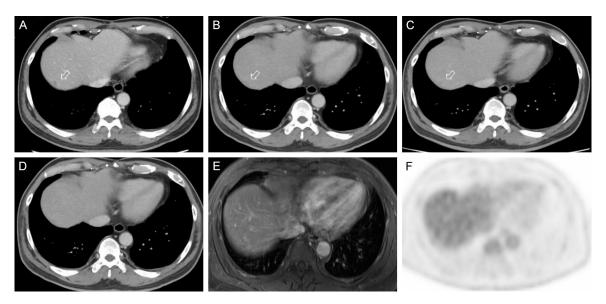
Evolutionary changes in liver metastasis at (A) 3, (B) 6, (C) 9, and (D) 12 months after pancreatic tumor resection. Magnetic resonance imaging (E) and positron emission tomography (F) performed 12 months after pancreatic tumor resection also demonstrate complete resolution of the liver metastasis. Arrow: liver metastatic lesion.
